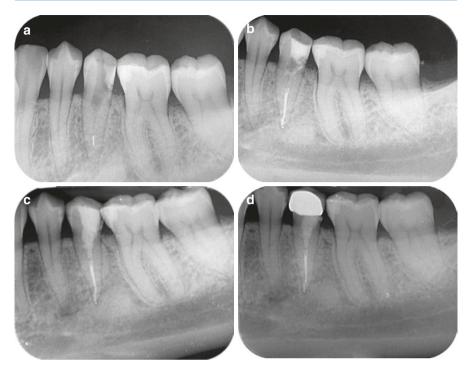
(a) Preoperative radiograph as submitted by the referring dentist with extensive removal of tooth structure in the crown and in the coronal root third and a fragment in the apical third. (b) Unsuccessful efforts to retrieve it with the file bypass technique resulted in its extrusion to the periapical tissues, as can be seen in the immediate post-obturation radiograph. (c, d) The 3- and 12-month scheduled clinical and radiographic recall examinations revealed uneventful healing
